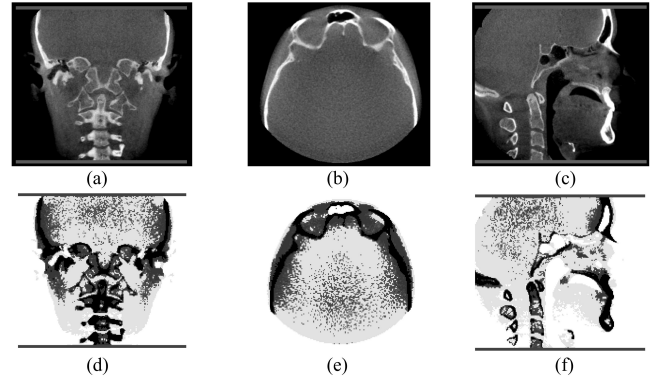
(a) Coronal, (b) Transverse, and (c) Sagittal of CT images; (d) Coronal, (e) Transverse, and (f) Sagittal of MagicDose constructed model.
